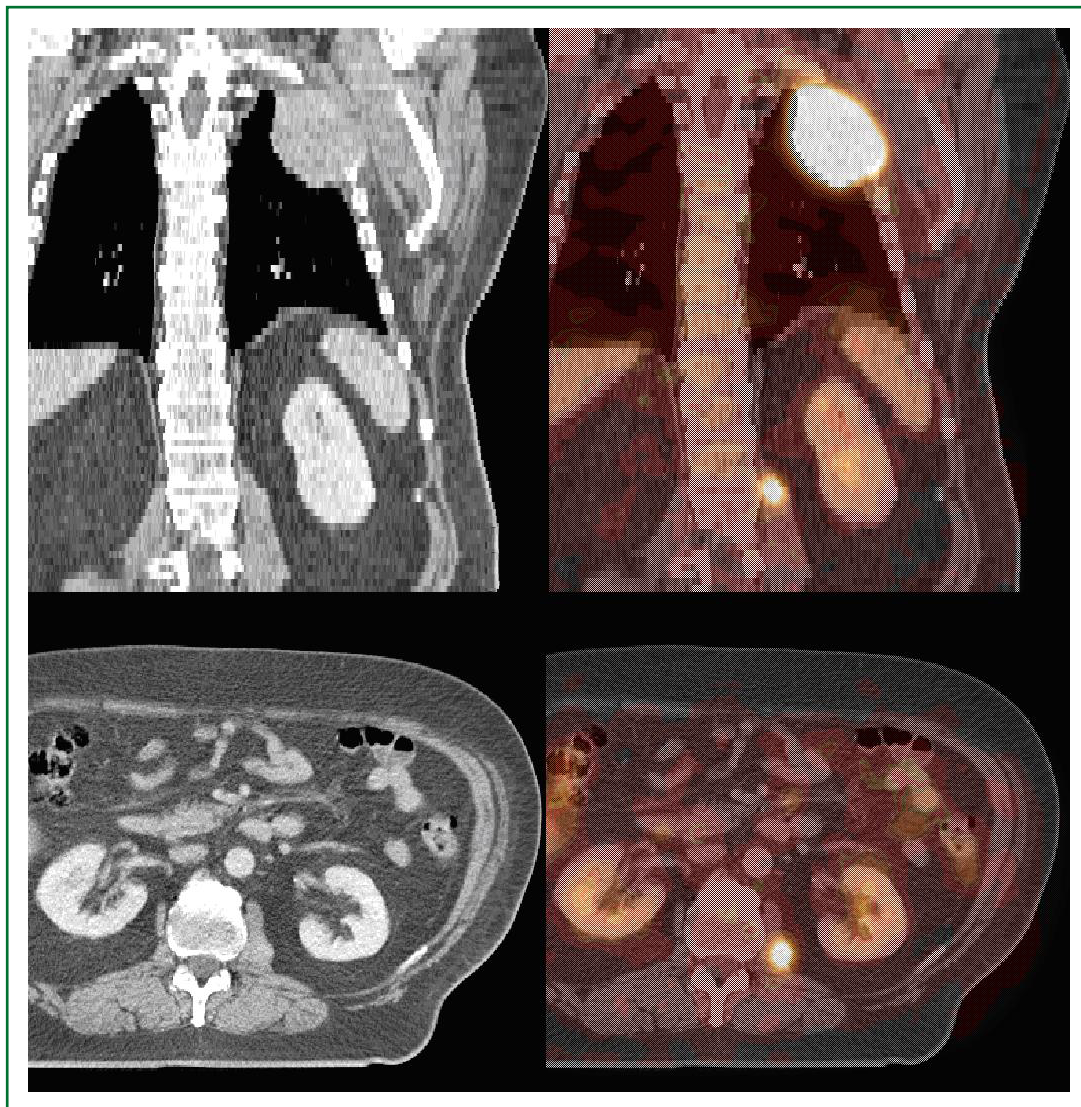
CT images in coronal (upper left) and axial (lower left) cuts paired with PET/CT fused images in coronal (upper right) and axial (lower right) cuts. Both the thoracic primary and the left psoas metastasis can be clearly identified in the PET/CT fusion.
